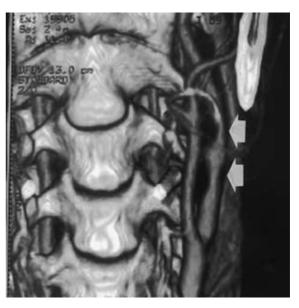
Three-dimmentional CT angiography shows an irregular stenosis of the left ICA. White arrows indicate left internal carotid artery.
